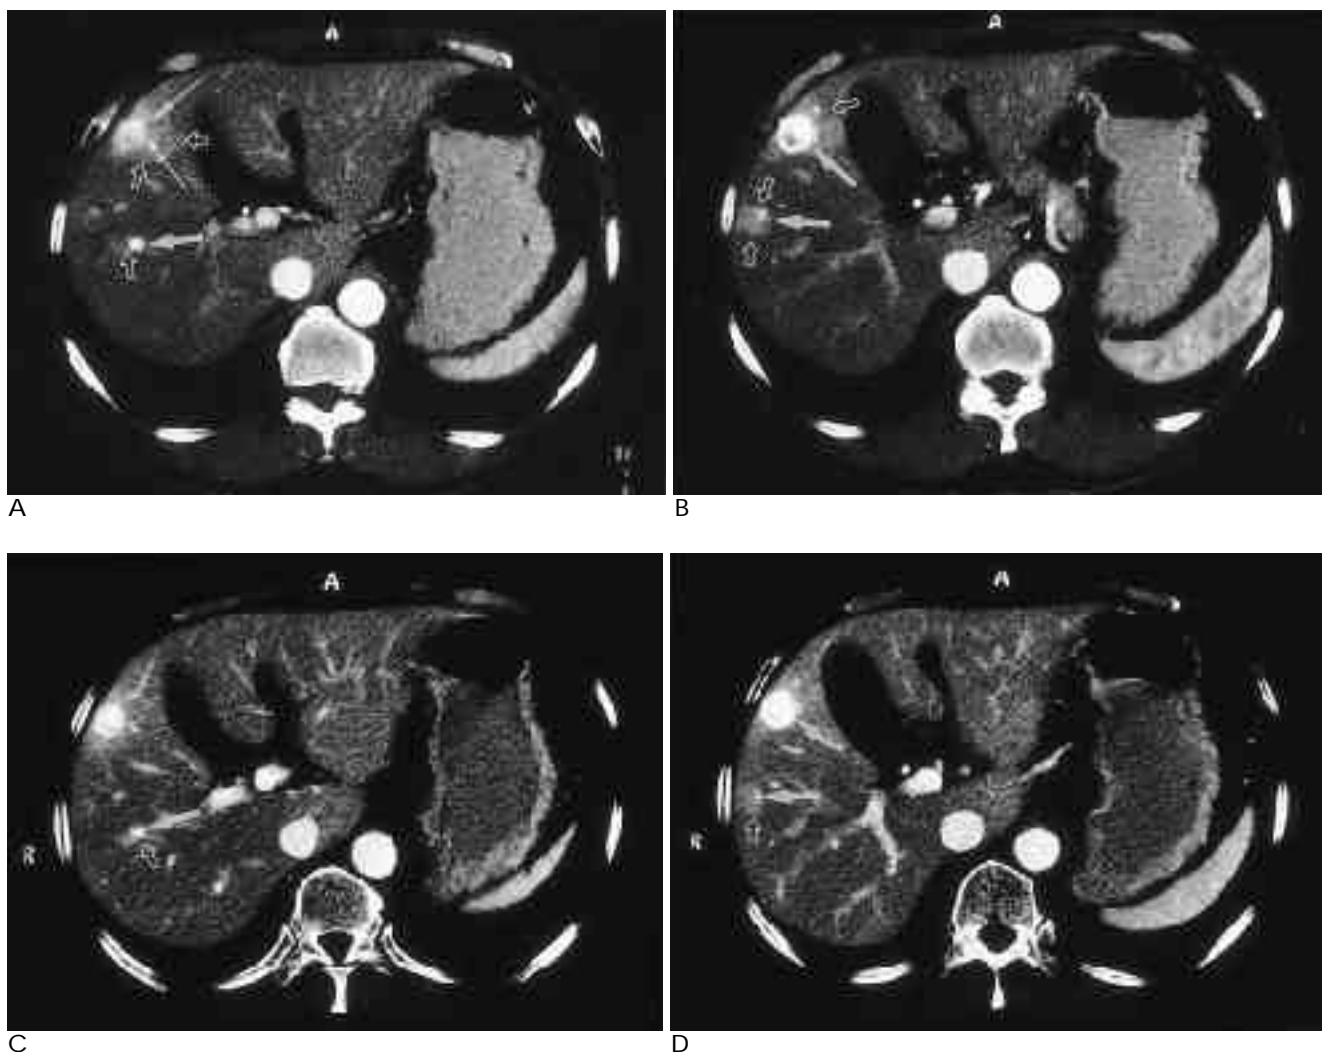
Three hemangiomas with wedge-shaped parenchymal enhancements in the periphery to the tumors in a 70-year-old man. Two consecutive CT scans during the hepatic arterial phase(A, B) show three small hyperattenuated nodules(arrows) and wedge-shaped homogeneous hyperattenuated areas(open arrows) peripheral to the nodules. Branches of the portal vein(thin arrows in A) are early opacified, suggesting the presence of an arteriportal shunt. CT scan during portal venous phase(C, D) show still hyperattenuated nodules(arrows) and peripheral wedge-shaped hyperattenuated areas(open arrows).
